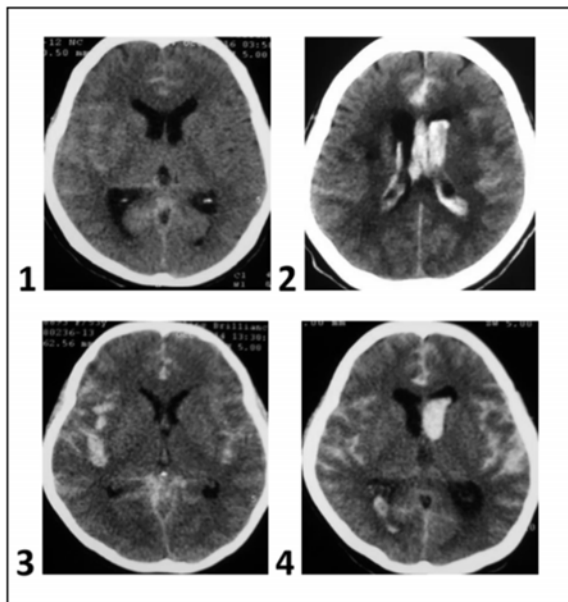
Modified Fisher subarachnoid hemorrhage CT grading: (1) grade 1 minimal SAH and no intraventricular hemorrhage (IVH); (2) grade 2 minimal SAH with bilateral IVH; (3) grade 3 thick SAH without bilateral IVH; (4) grade 4 thick SAH with bilateral IVH^(11,19).
